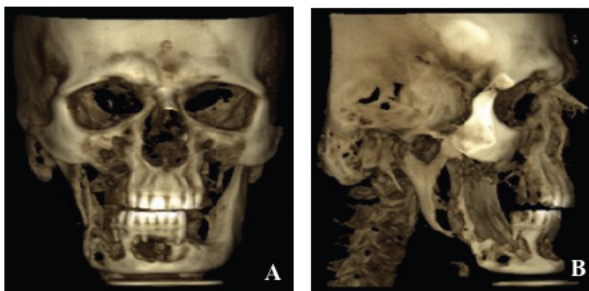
Three dimensional CBCT. A, the lesion is located in anterior part of the mandible, the distal lesion demonstrated mild expansion of buccal plate. B, the anterior posterior extension of the lesion from second premolar.
